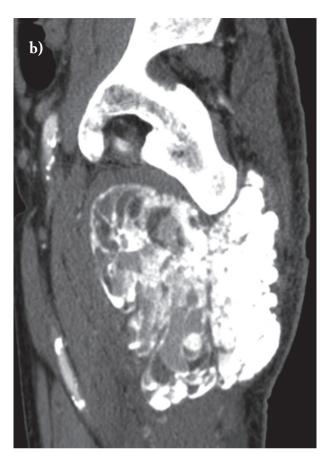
MPR reconstructions on coronal (a) and sagittal (b) planes and 3D reconstructions (c) CT scans better depict lesion localization and extension around the left hip joint and the upper thigh
